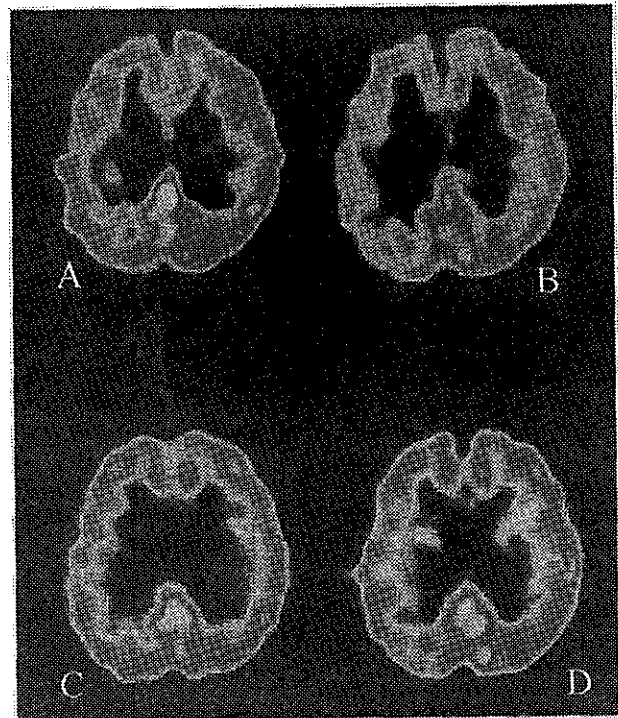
Single photon emission computed tomography (SPECT) findings of 54-year old male complaining of transient left hemiparesis. (A) SPECT at resting before bypass showing the relative hypoperfusion area in right cerebral hemisphere. (B) SPECT at acetazolamide (ACZ) challenge before bypass showing the poor response to ACZ in right cerebral hemisphere. (C) SPECT at rest after bypass showing the improvement of the blood flow. (D) SPECT at ACZ challenge after bypass showing the improvement of the response to ACZ
